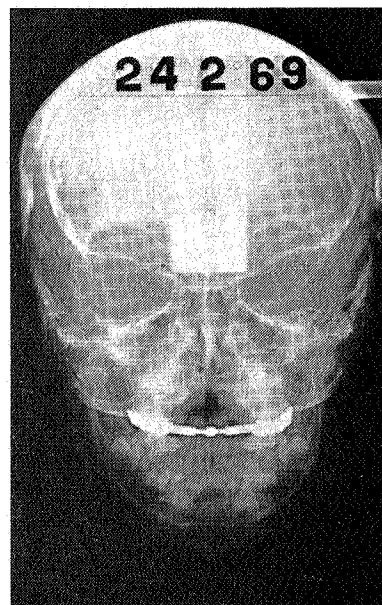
Palate Expansion — X-ray during expansion demonstrating the inter-maxillary widening.
